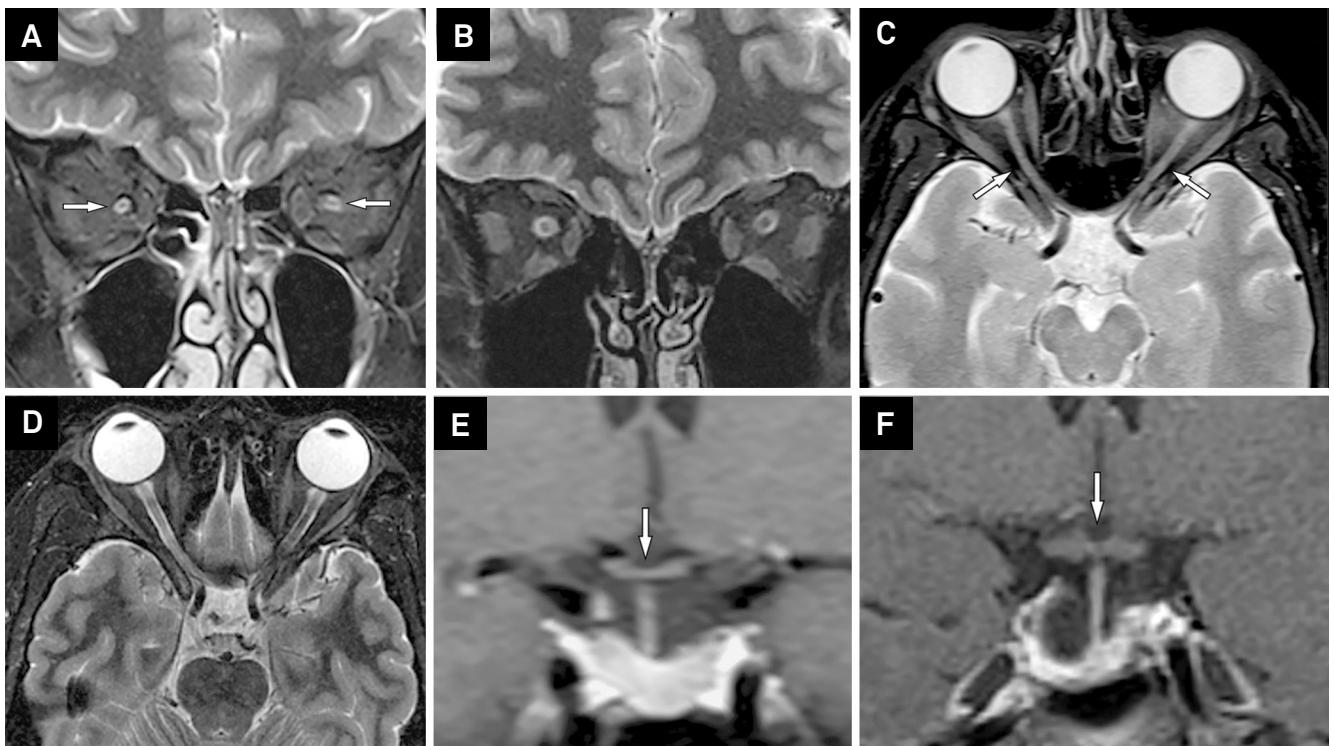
MRI of Wolfram patient (A, C, E) compared with an age-matched healthy subject (B, D, F). Coronal T2-weighted image using fat saturation (A) demonstrates striking hypoplasia of both optic nerves in the orbits (arrows); note the normal appearance in the healthy subject (B). The same sequence in the axial plane shows the same finding in the patient (C - arrows), compared to the normal aspect (D). Optic chiasm is also hypoplastic in Wolfram patient, demonstrated in a coronal post-contrast T1-weighted image (E - arrow), while a normal optic chiasm is appreciated in the healthy subject (F - arrow).
